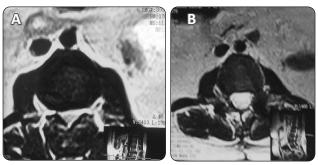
(A) Pre- and (B) post-operative axial T2 MRI of L2-3 level showing central lumbar spinal canal decompression.
